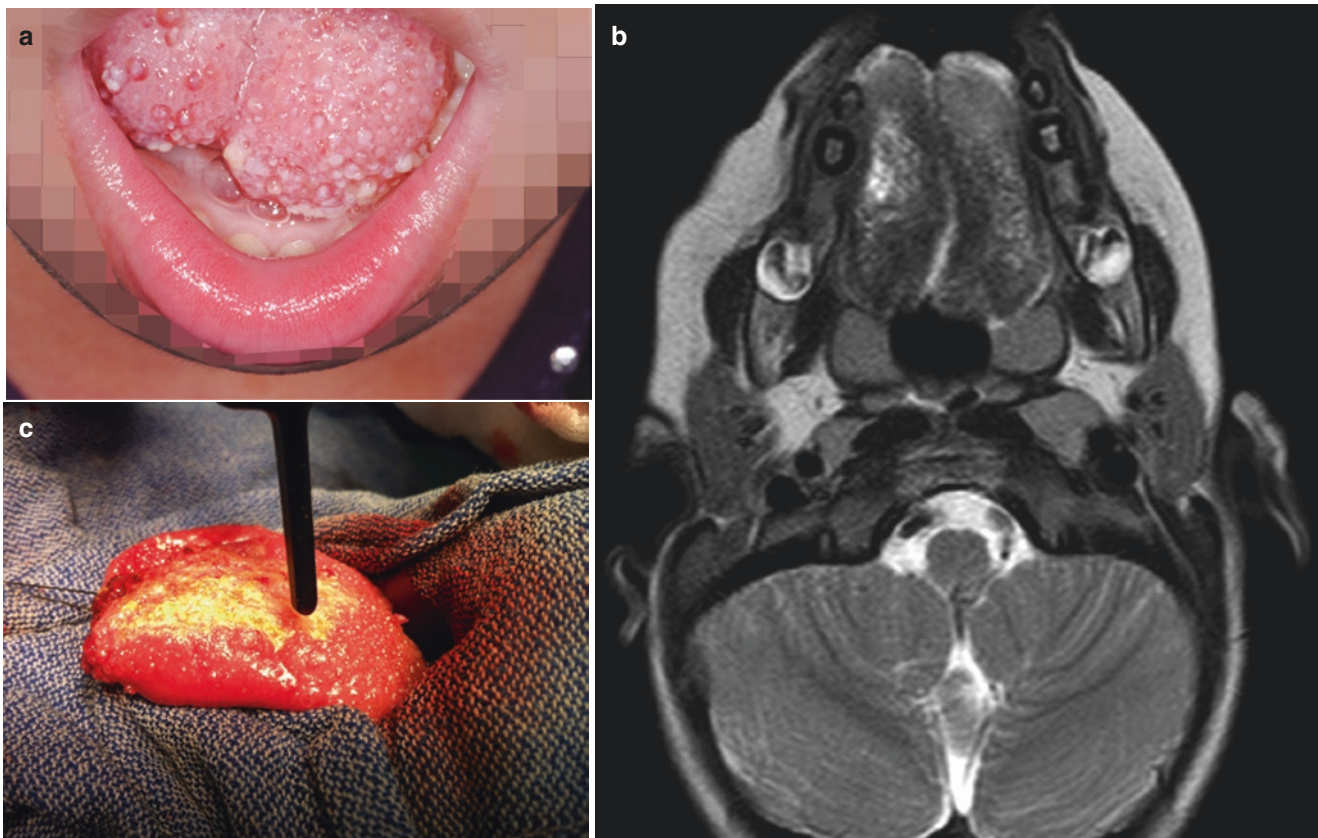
(a) “Vesicular” appearance of the tongue seen with microcystic lymphatic malformation. Vesicles appear “pus,” clear or “bloody” filled. (b) Axial T2-weighted MRI demonstrates the bifid appearance of the tongue
